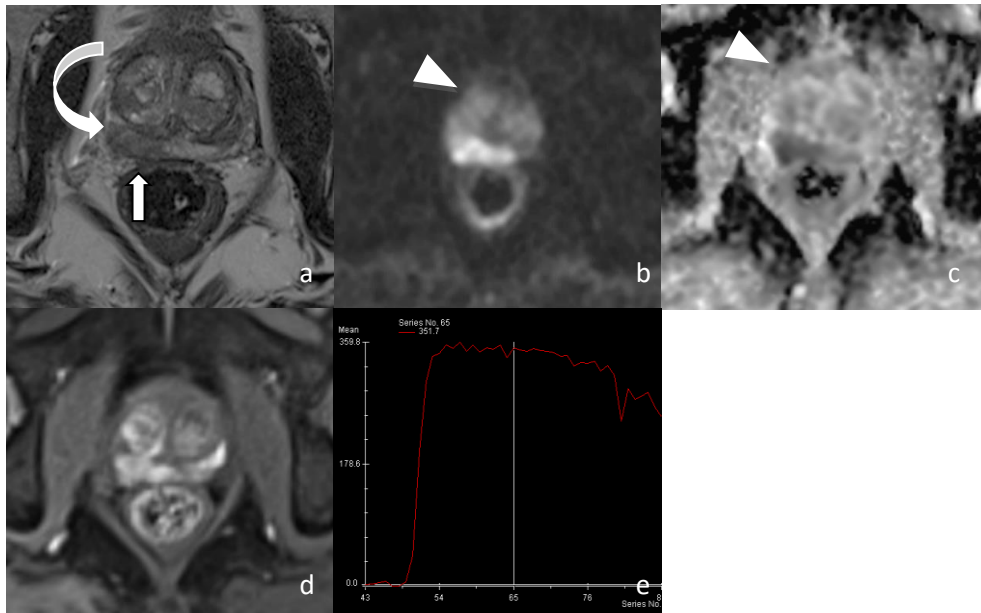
An example of Multiparametric MR of the prostate. Axial (a) T2 weighted MR image shows a contact between the tumour (curved arrow) and the anterior rectal wall (arrow). The normal low signal of the anterior rectal wall (arrow) has disappeared suggesting an invasion. DW MR image (b, with b value = 1200) shows high signal of the tumoural tissue (arrowhead) with low ADC values on the apparent diffusion coefficient (ADC) map (c) ($660\text{mm}^2/\text{sec}$) (arrowhead). Post-contrast image and DCE curve within the lesion (e, f) show type 3 curve (f).
